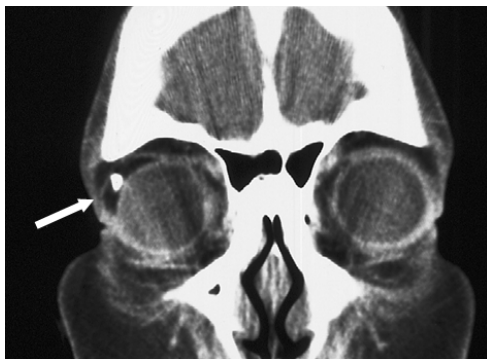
A dermoid cyst in a 49-year-old woman. A coronal CT scan shows a fat-containing mass with nodular calcification in the superior lateral aspect of right orbit (arrow).
